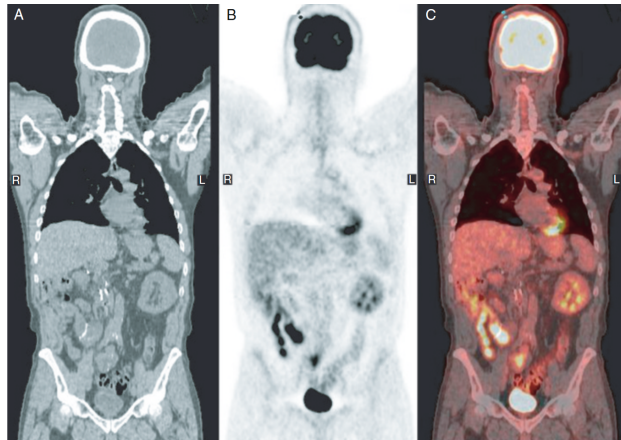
Imaging via PET/CT: the left plot shows the image acquired by a CT, the middle plot the corresponding PET scan and the right plot represents the fused image of a PET/CT combination [15]
